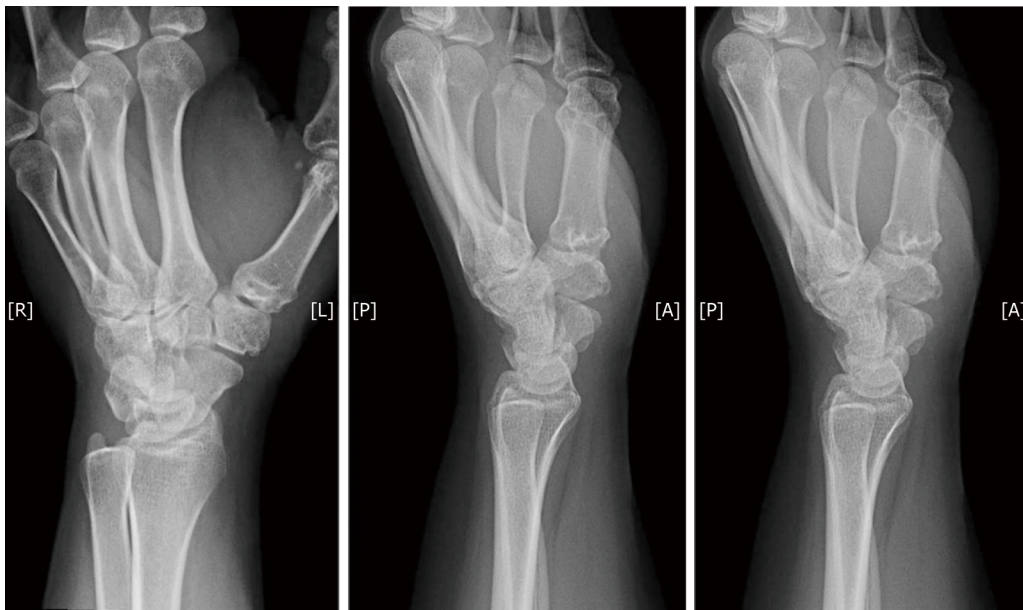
X-ray of patients' left hand in three planes showing signs of basal joint arthritis of her thumb.
